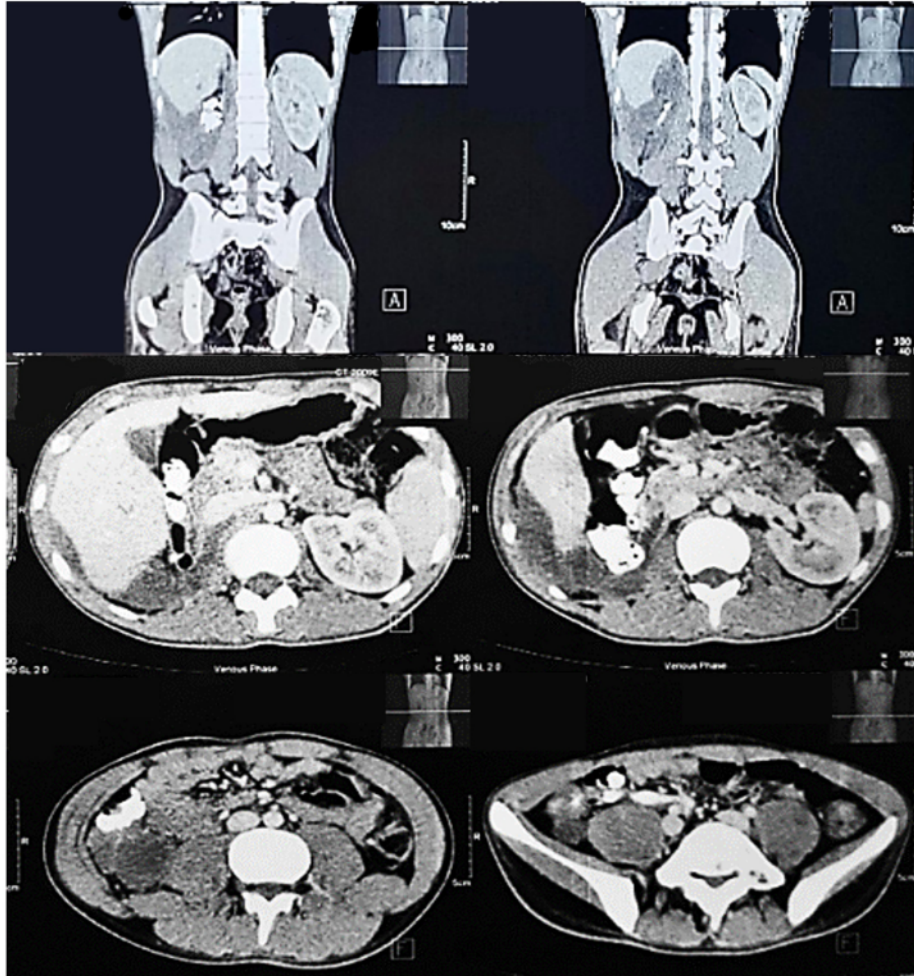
Abdominal CT-scan six months after 6 cycles of chemotherapy (R1).
